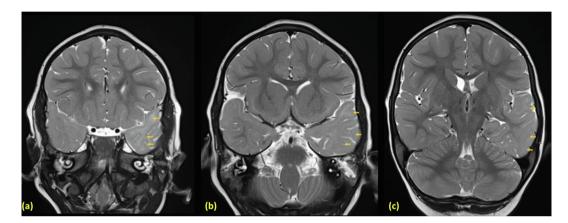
MRI Brain with coronal oblique T2 images of the temporal lobes from anterior to posterior (a) - (c): There is asymmetric T2 high signal within the left anterior temporal lobe and polar white matter (arrows) consistent with an underlying cortical dysplasia. The hippocampi have a normal appearance. The right temporal lobe myelination is within normal limits for age.
